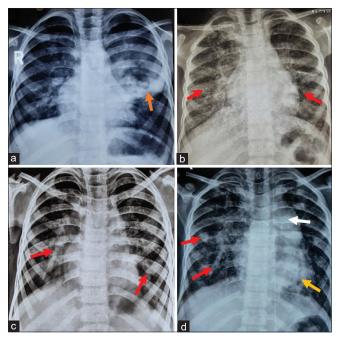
Chest X-rays during the course of the illness. (a) X-ray during the first episode showed left upper lobe consolidation with breakdown areas (orange arrow). (b) X-ray during the second episode showed reticulonodular opacities (red arrows) in both lungs. (c) X-ray during a subsequent episode showed multiple reticulonodular opacities (red arrows) in both lungs. (d) X-ray during the current admission showed retrocardiac cosnolidation (gold arrow) with bilateral reticulonodular opacities (red arrows) with prominent pulmonary conus (white arrow)
